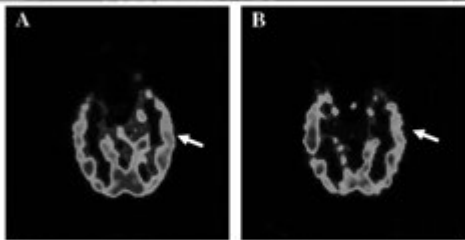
[<sup>18</sup>F]Methylsalsolinol ([<sup>18</sup>F]MeNTD) and [<sup>18</sup>F]fluorodesoxyglucose ([<sup>18</sup>F]FDG) positron emission tomographic images in a 35-year-old woman with a right-sided temporal lobe epileptic focus. In the [<sup>18</sup>F]FDG study, there is approximately 25% reduction in [<sup>18</sup>F]FDG uptake. In the [<sup>18</sup>F]MeNTD study, there is a 35% increase in [<sup>18</sup>F]MeNTD binding in the temporal lobe in a region corresponding the hippocampal region and a 17% decrease in the ipsilateral amygdala.
